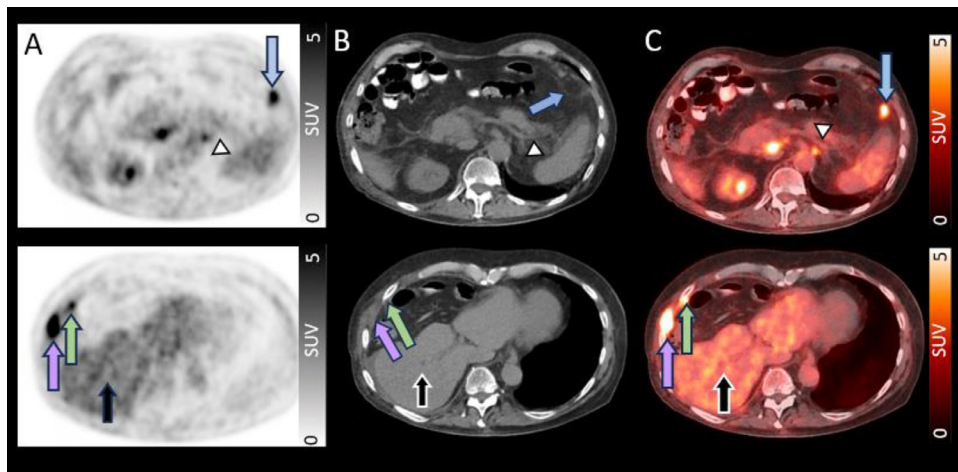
Follow-up FDG-PET/CT taken 14 months after discontinuation of pembrolizumab, initiation of steroid, and subsequent non-pembrolizumab systemic therapies showed a complete resolution of previous FDG avidity of the right hepatic artery (black arrow) and splenic artery (white arrowhead) in (A) PET only; (B) CT only; (C) fused PET/CT despite progression of malignant pleural mesothelioma, as seen with increased size of left upper abdominal implant with SUV_{max} of 11.2 (blue arrow), persistent right-sided chest wall mass with a SUV_{max} of 13.6 (purple arrow) and a new right pleural focus (green arrow) with SUV_{max} of 9.7, supporting the diagnosis of pembrolizumab-related vasculitis.
